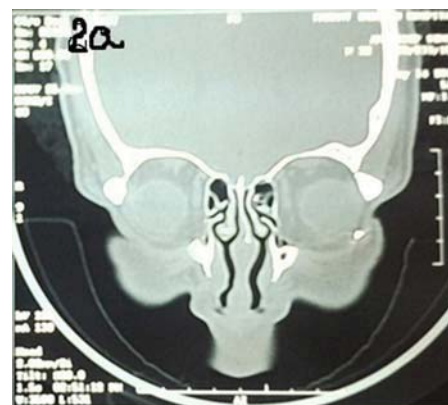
CT showing OFB.
